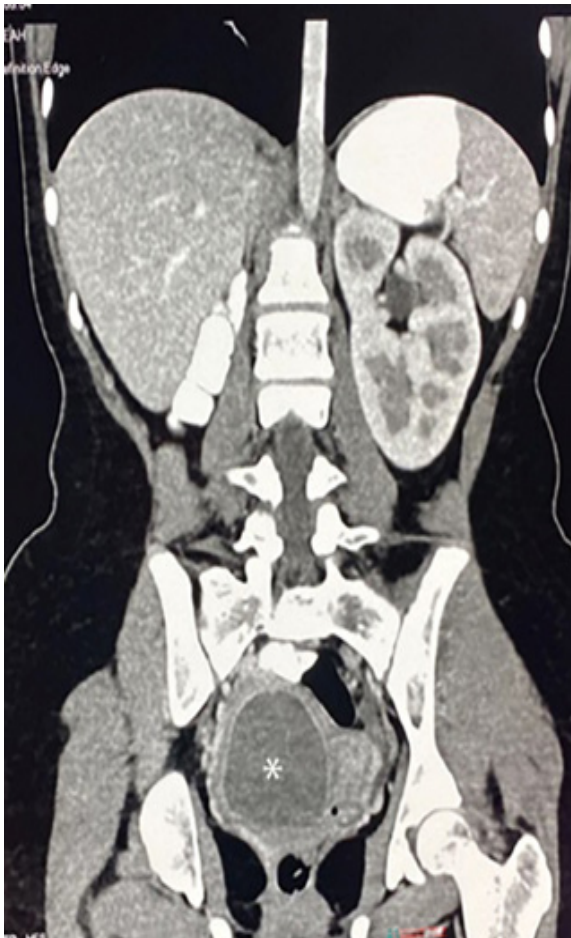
Magnetic resonance image of right hematometocolpos (6×7 cm) in a 12-year-old girl (white asterisk: right hematometocolpos).
